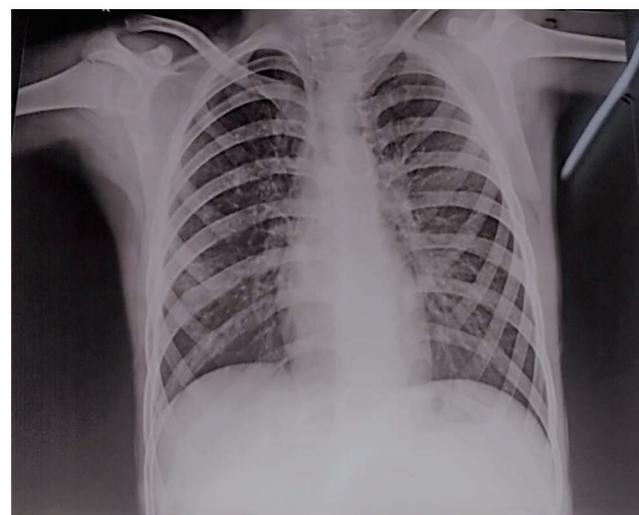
Follow up chest X-ray showing resolution of pleural effusion with treatment.
